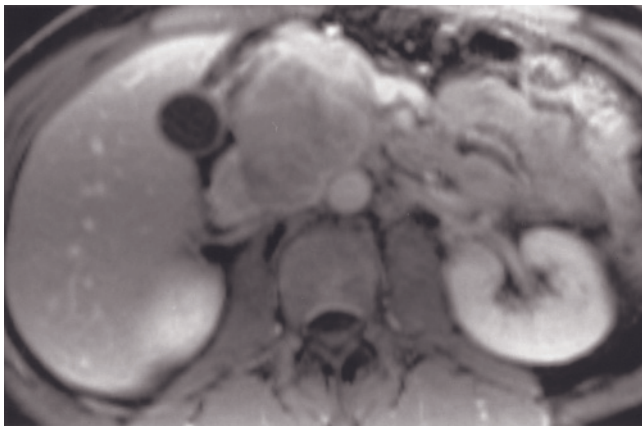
Testicular cancer. Coronal (a) and transverse (b) T2-weighted SS-ETSE, transverse SGE (c), and interstitial-phase gadolinium-enhanced fat-suppressed SGE (d) images. There is a large left retroperitoneal mass that demonstrates heterogeneous internal signal on T1- and T2-weighted images and possesses thin septations that enhance after contrast administration. This is consistent with a large nodal mass secondary to nonseminomatous testicular cancer. Coronal T2-weighted SS-ETSE (e), transverse
